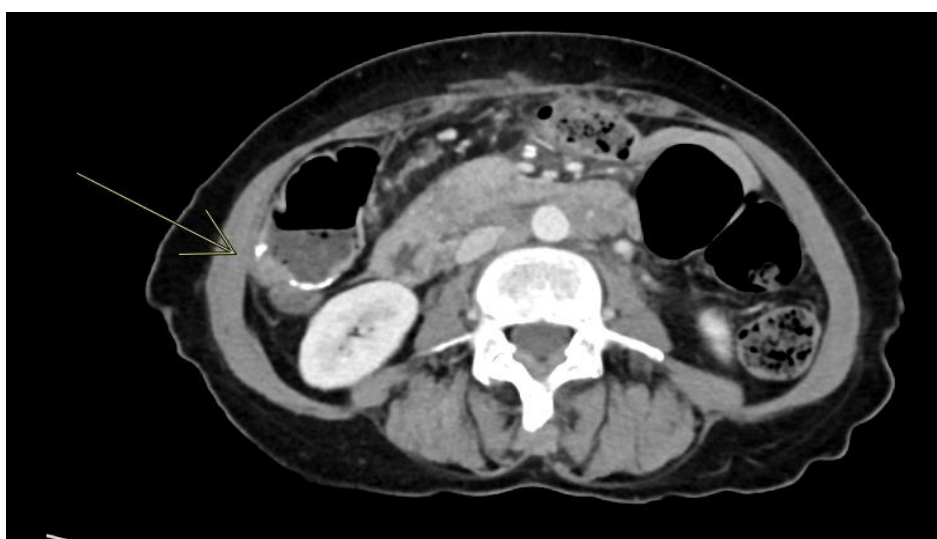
CT abdomen and pelvis with contrast after resection the colonic anastomosis at right upper abdomen showing focal eccentric thickening on the anterolateral side of about 2.1cm x 1.2cm in length and thickness.
